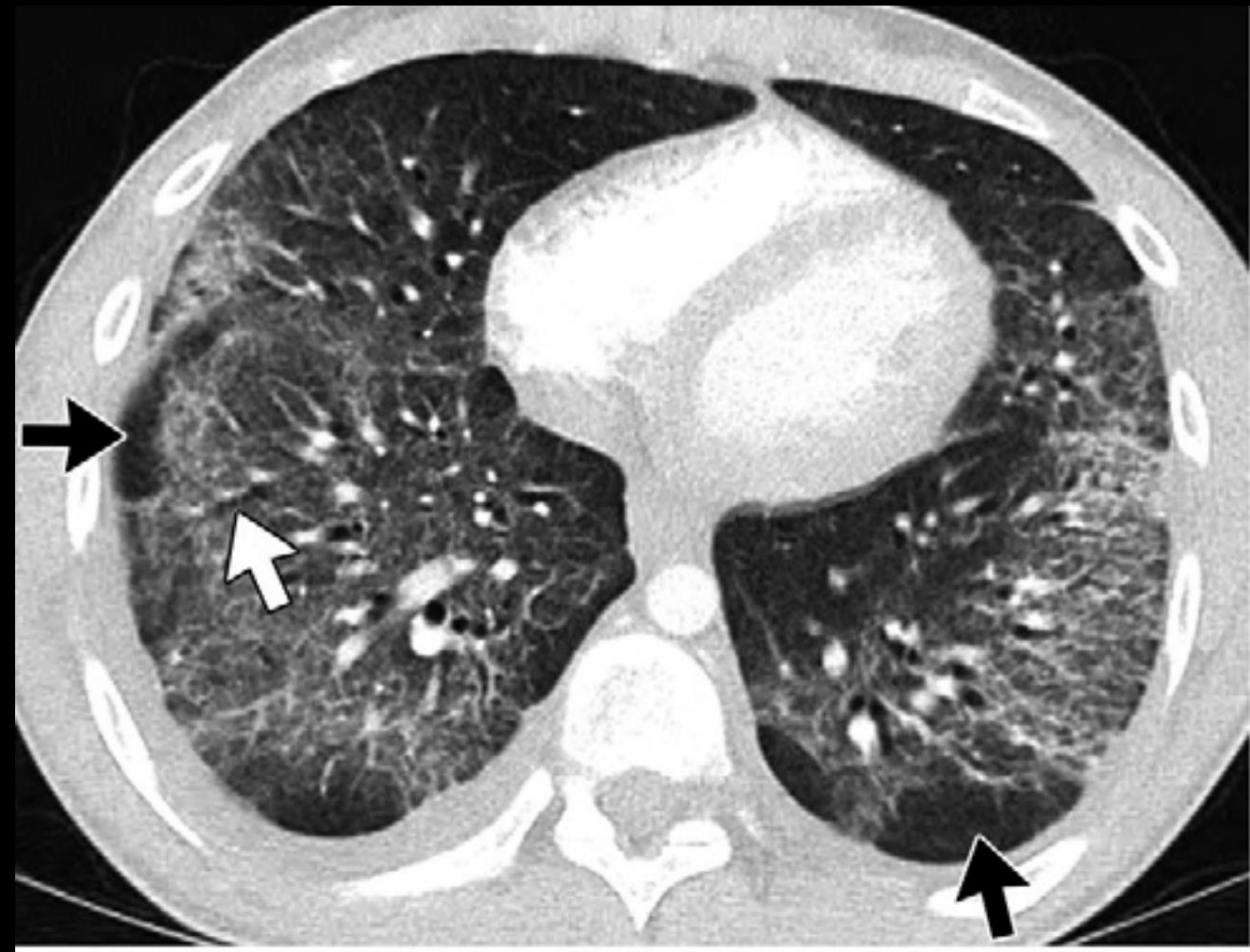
A-B, Atypical patterns in e-cigarette or vaping-induced lung injury (EVALI). A, CT image of a 49-year-old man who vaped tetrahydrocannabinol (THC) and nicotine shows common imaging findings associated with a diffuse organizing pneumonia (OP) pattern of EVALI in the left lung with diffuse ground-glass opacity (GGO) with subpleural (black arrow) and peribronchovascular (PBV) sparing (white arrows) with only minimal involvement of the right lung. B, Coronal reformatted CT image of a 36-year-old man who vaped nicotine presenting with dyspnea and cough for nearly 4 months shows a diffuse GGO OP pattern with PBV sparing (arrows). Additionally, there are numerous cystic spaces, some with surrounding foci of consolidation (asterisks), which led to the atypical classification. The cysts are likely caused by areas of parenchymal destruction and have been reported.
